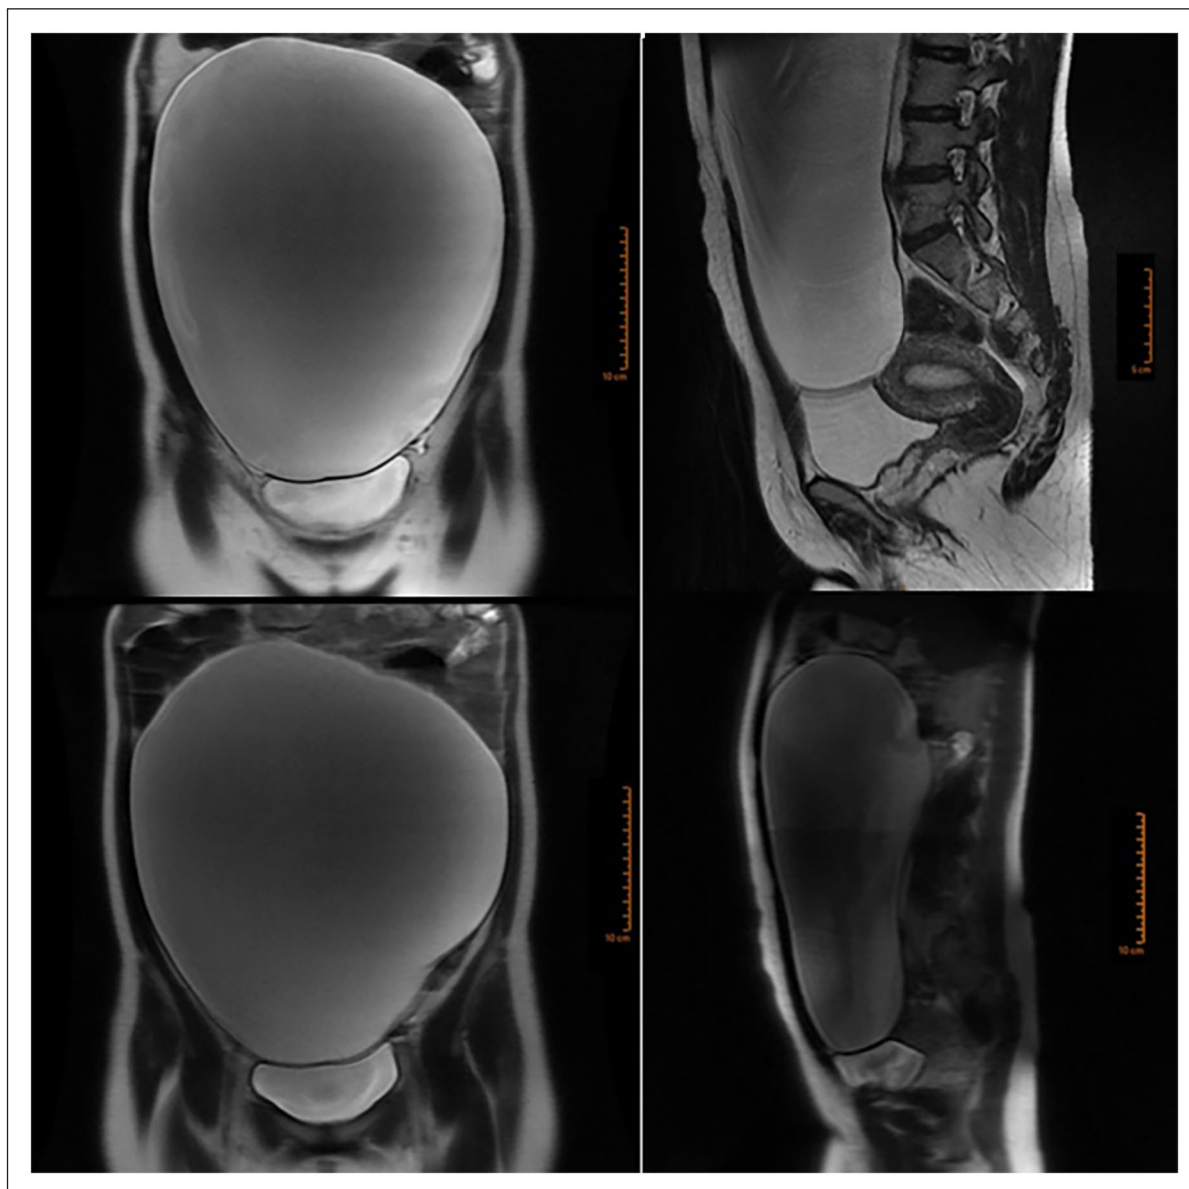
Abdominal-pelvic MRI, coronal and sagittal views.
